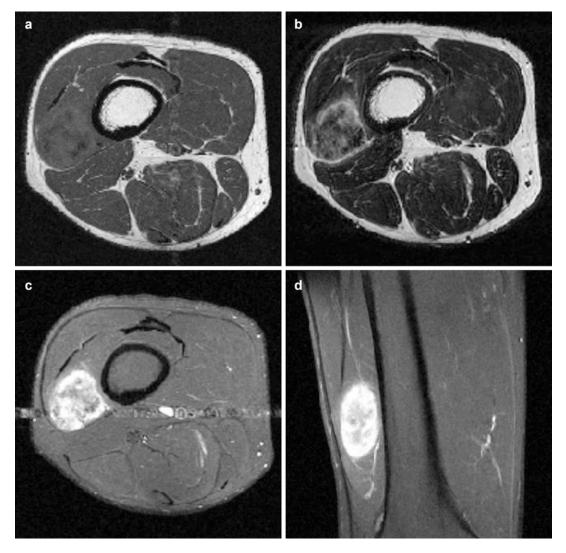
(a–d) Extraskeletal osteosarcoma of the thigh in a 48-year-old male (reproduced from Vanhoenacker et al. [26], with permission): an axial spin-echo T1-weighted MR image; (b) axial fast spin-echo T2-weighted MR image; (c, d) axial (c) and coronal (d) spin-echo T1-weighted MR images with fat suppression after gadolinium contrast injection. Ovoid soft tissue mass, deeply located within the muscle compartment
